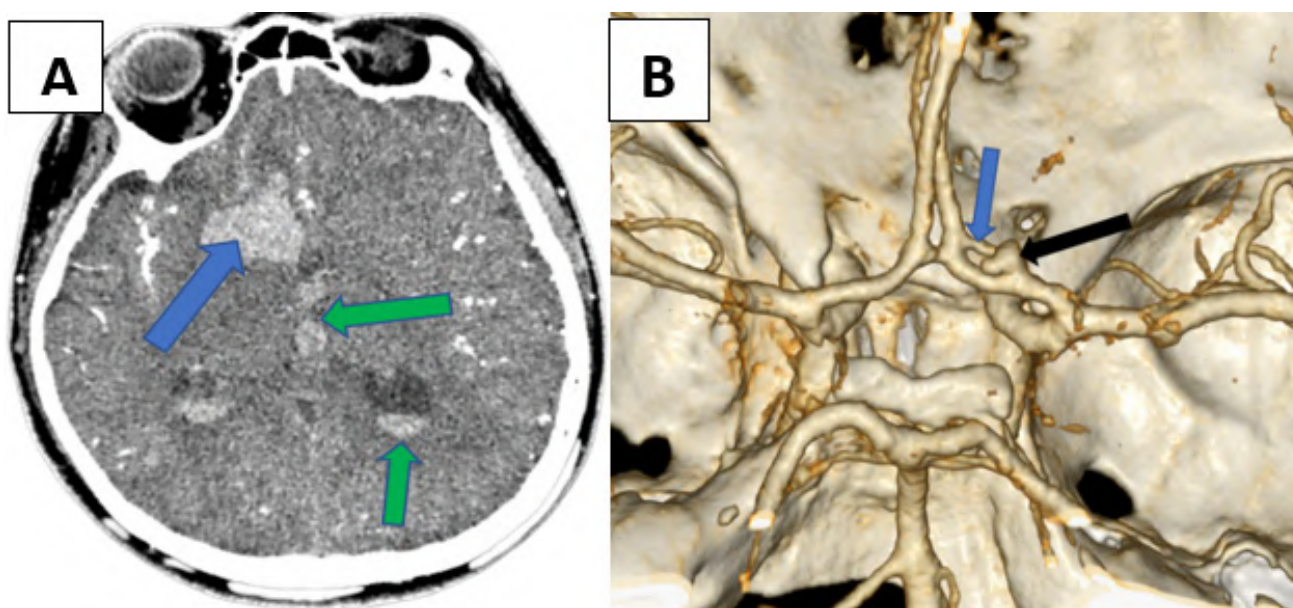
A- Preoperative CT brain showing a right frontal intracerebral hematoma (blue arrow) and Fischer grade 4 subarachnoid hemorrhage. B- Preoperative CTA shows a fenestrated right A1 connecting to the right A2 (blue arrow) with a saccular aneurysm (black arrow) arising from the origin of the fenestration.
